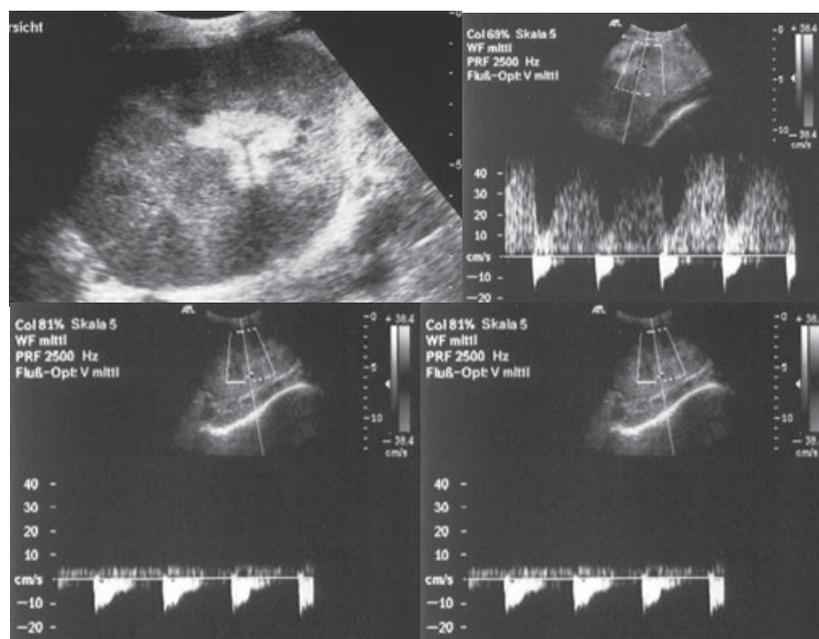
Ultrasound examination: swollen graft, missing telediastolic signal.
